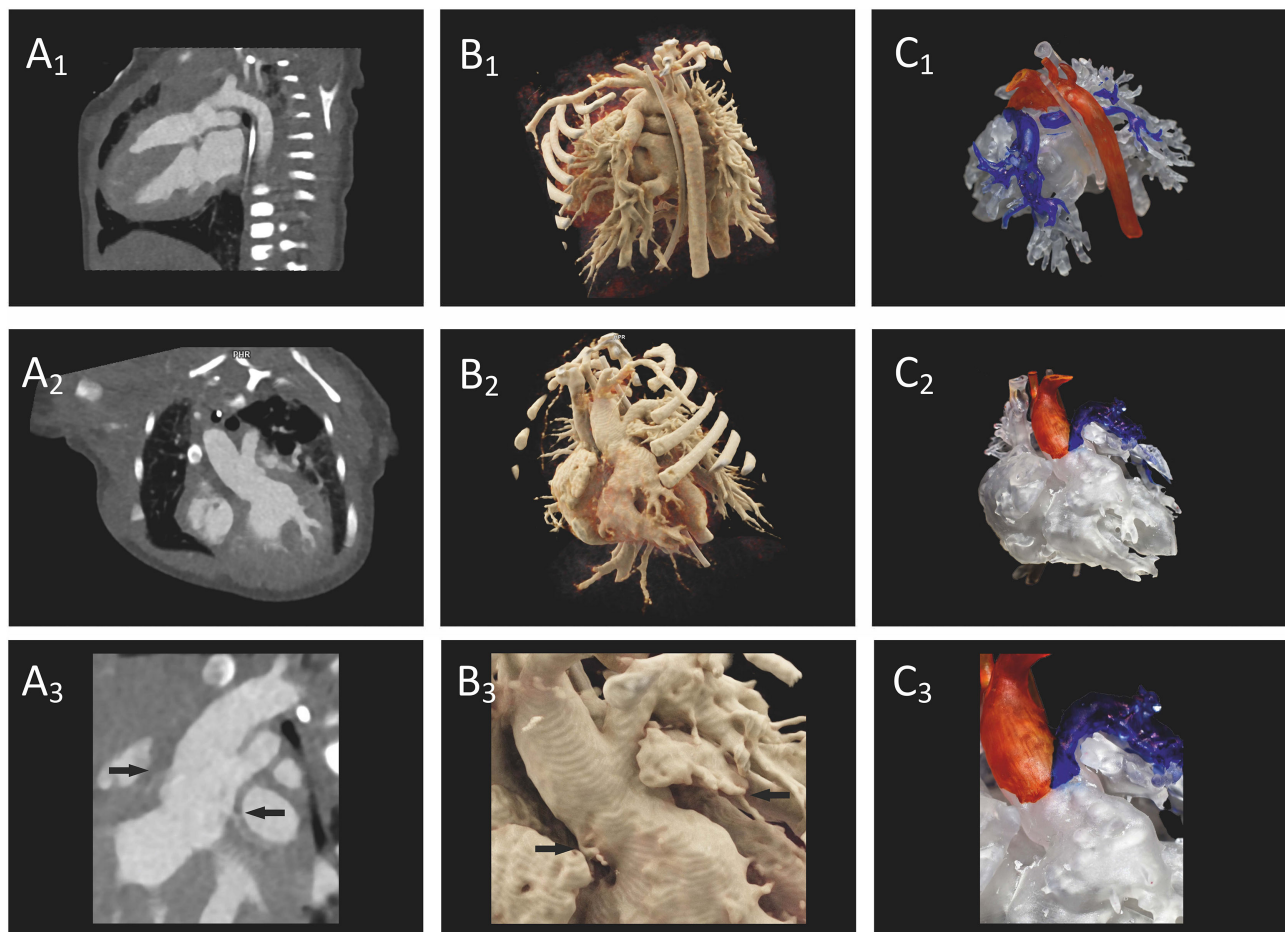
Preoperative imaging of a patient's heart with truncus arteriosus communis from two different perspectives. (A1–A3) A direct comparison of CT on a 2D screen (2D imaging), (B1–B3) cinematically rendered hologram, and (C1–C3) 3D printing. In (A3), the coronaries (arrows) show only a weak contrast, but the 3D view can be demonstrated as a cinematically rendered hologram (B3). A reconstruction of the coronary structure for 3D printing was not possible in this case (C3).
